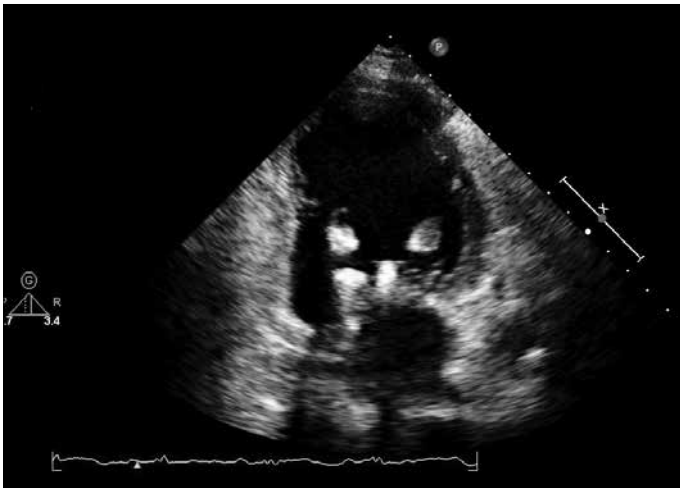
After the procedure control transthoracic echocardiography demonstrates chaotic echoes in the posteromedial papillary muscle in apical two-chamber view
